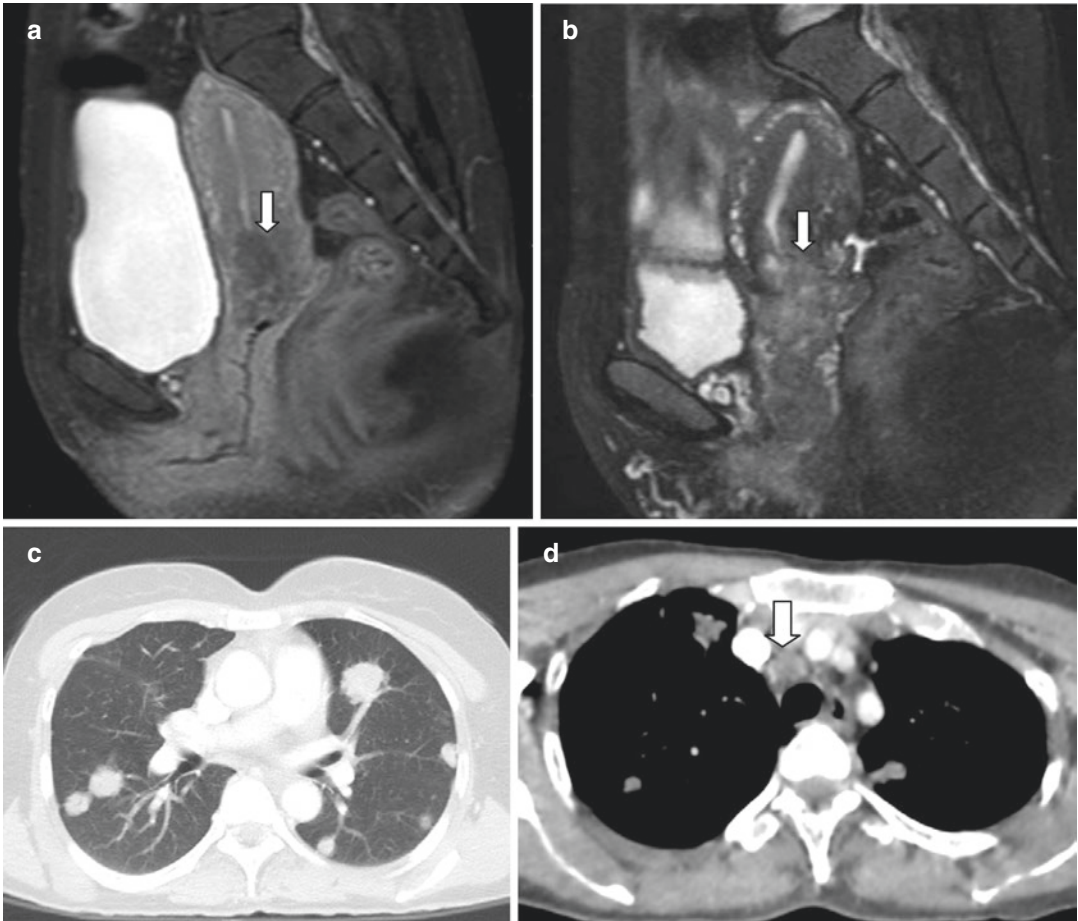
Cervical cancer with pulmonary and mediastinal nodal metastases. (a, b) Sagittal T2W and T1W contrast MRI scan showing cervical growth (white vertical
